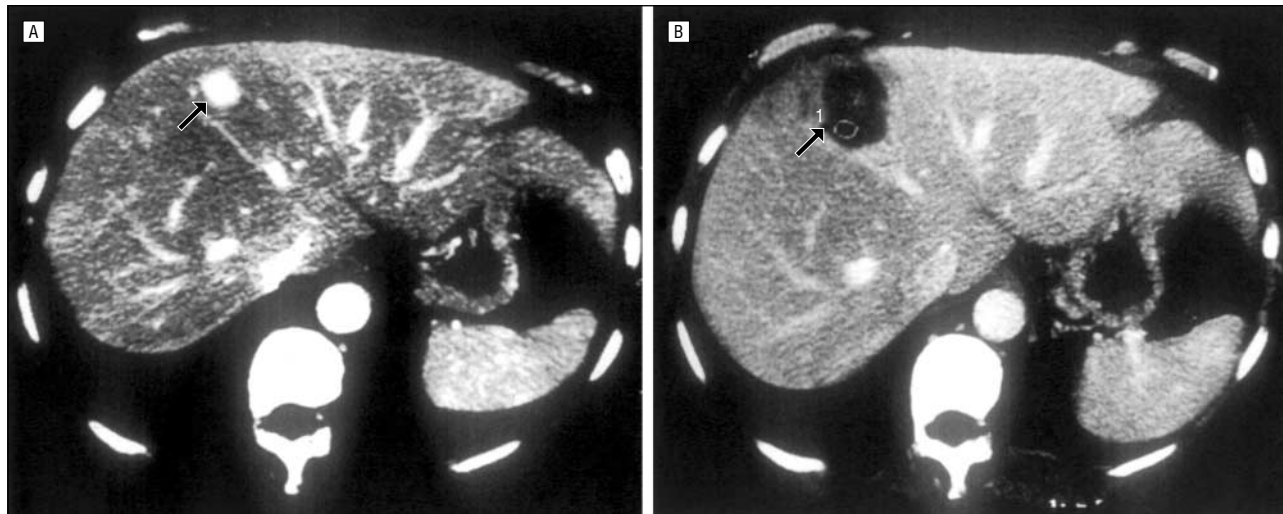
Computed tomographic scan demonstrating successful treatment of a hepatocellular carcinoma. A, Before treatment, the uptake of contrast within the tumor (arrow) indicates active tumor vascularization. B, Following treatment by percutaneous cryosurgery, there is absence of uptake of contrast within the tumor (arrow), indicating successful tumor devascularization.
